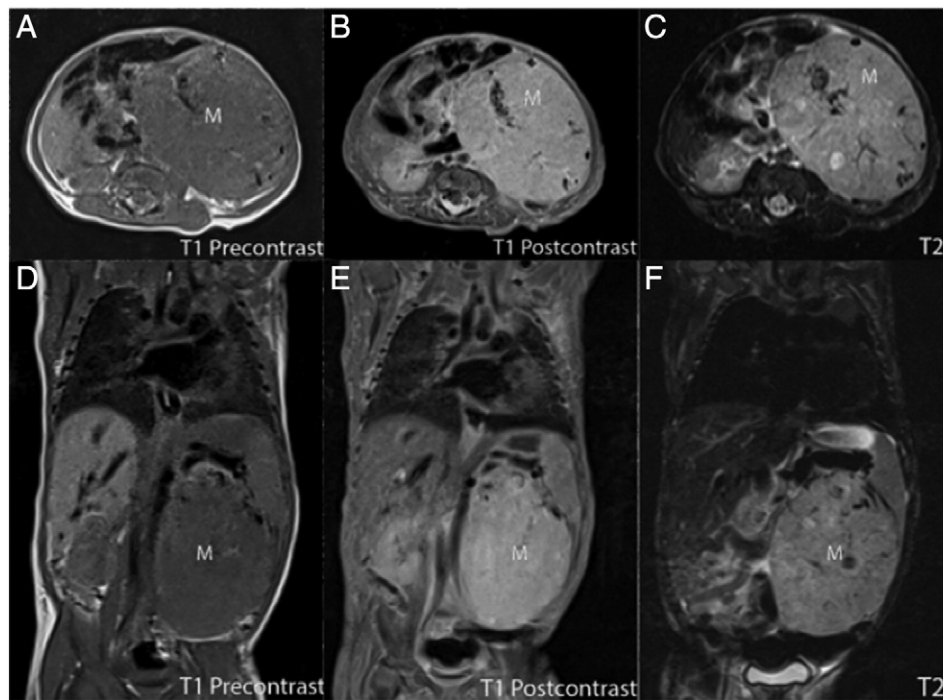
Multiple MRI sequences of the abdomen localize the mass to the splenic hilum and characterize the tissue. On T1 precontrast images in axial (A) and coronal (D) planes the mass is low intensity with black areas that are either flow voids or hemosiderin from hemorrhage. The mass enhances fairly homogeneously after administration of contrast in both axial (B) and coronal (E) planes. On T2 weighted unenhanced images in axial (C) and coronal (F) planes the mass is heterogeneously bright in appearance.
